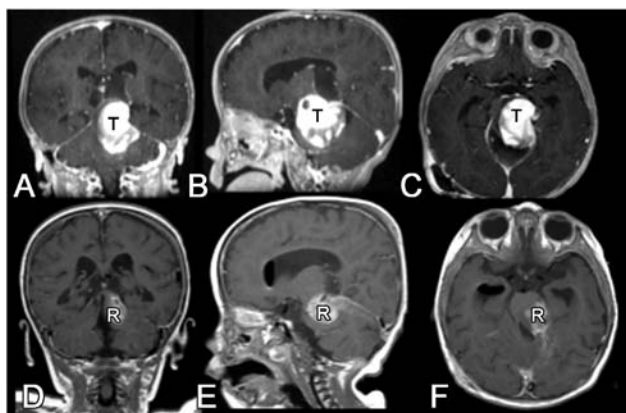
Dorsal focal-midbrain glioma (T) in a 9-month-old child. A) Coronal, B) sagittal, and C) axial T1-weighted MRI with contrast prior to surgery. D) Coronal, E) sagittal, and F) axial corresponding images after subtotal resection. Residual (R) was treated with chemotherapy.
